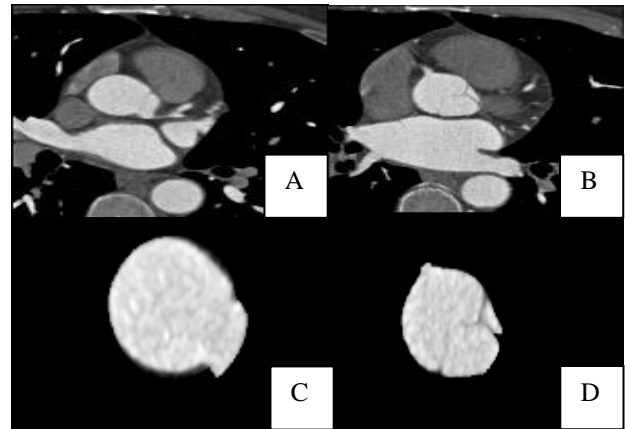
(a and b) Right and left ostia points (indicated by red arrows) on CTA image slices; (c and d) right and left ostia points on segmented ascending aorta cross sections.
